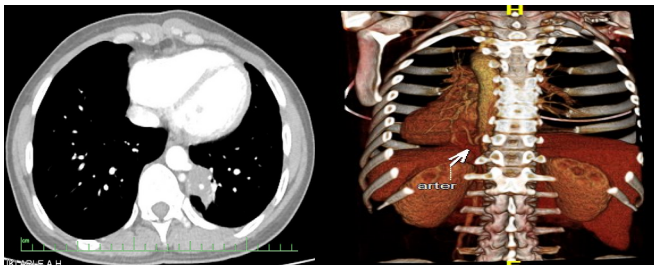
Thorax CT and CT angiography demonstrating 4 cm opacity in the left lower lobe (IPS) and feeding artery from the descending aorta.
